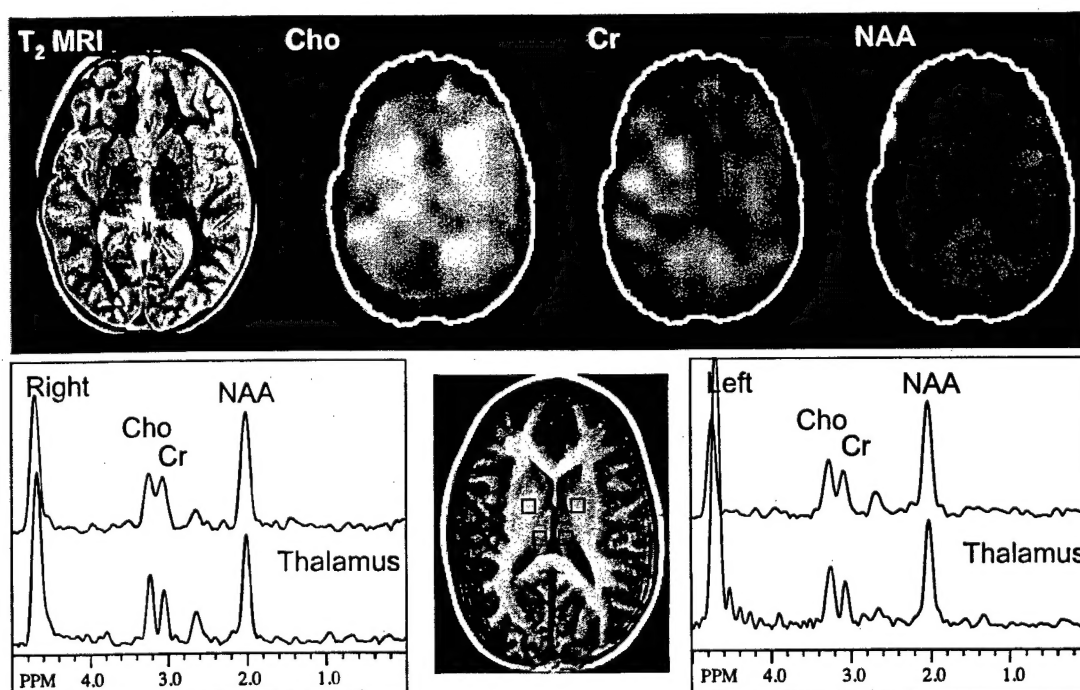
T1, T2 MRI and proton MRSI in an 8 year old control subject.
